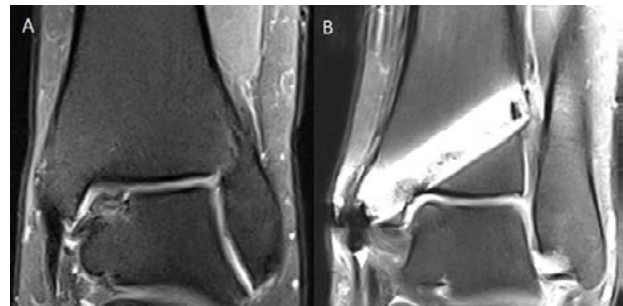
A: Coronal T2 section magnetic resonance images (MRI) of a grade 3 posteromedially located osteochondral defect of left talus (1.35 cm² size) in 17-year old female; B: 1-year follow-up coronal T2 section MRI showing complete filling of the defect and establishment of smooth articular surface
